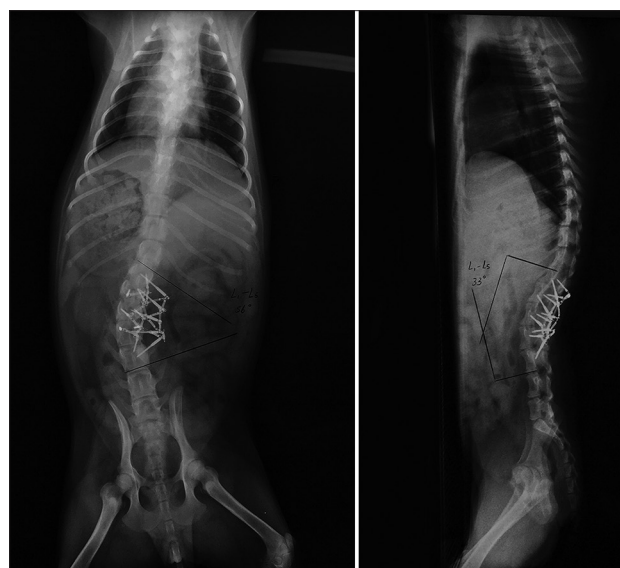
Posteroanterior and lateral radiographs of the spine 22 weeks after surgery.
